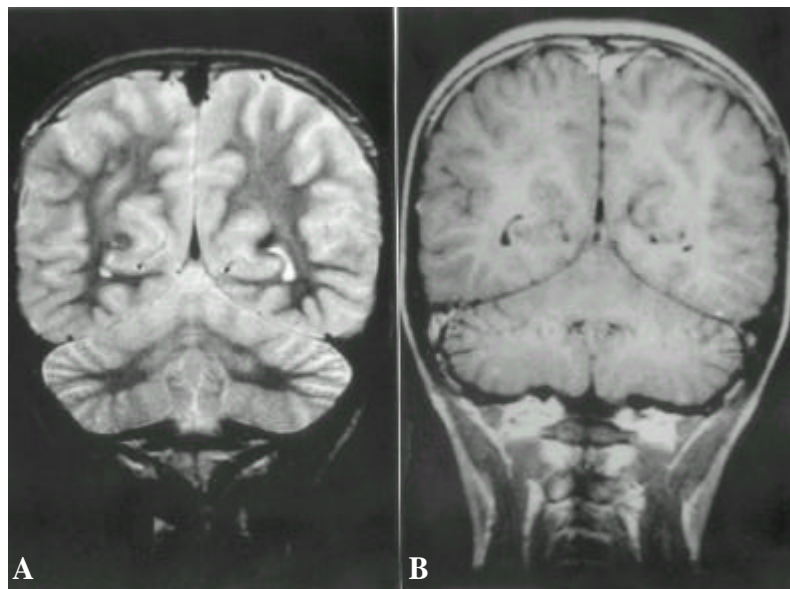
Follow-up brain MRI(coronal section) 3 months after antituberculous treatment. Marked decrease in number of multiple well-defined small nodules with peripheral rim enhancement is observed in both cerebral and cerebellar hemispheres, and brain stem. However multiple tiny enhancing nodules are still noted in both cerebral and cerebellar hemispheres.
